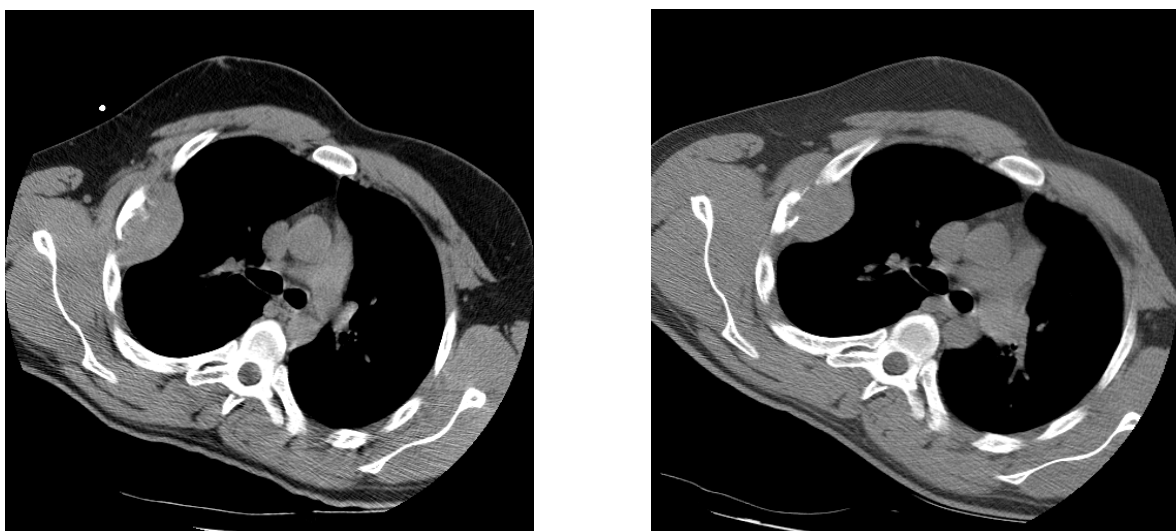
Computed tomography scans before surgical intervention (left: 21.05.02; right 07.06.02) <sup>[19]</sup>
